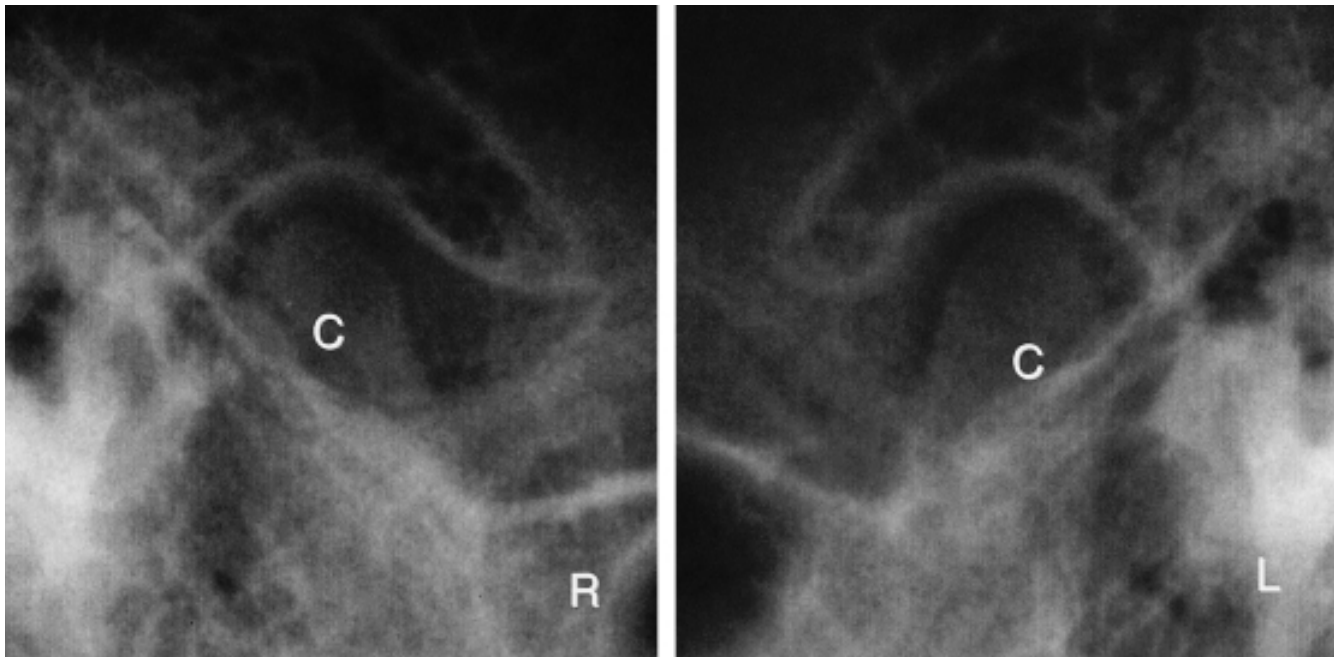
Transcranial X-rays taken at first examination (age 11 years, 9 months; C: condyle).
